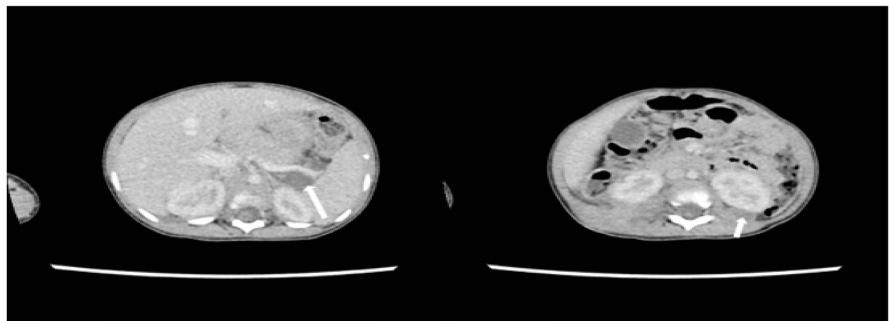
Axial contrast enhanced CT scans of the abdomen; shows a cystic lesions in the splenic hilum (long arrow) and another posterior to the left kidney (short arrow).
